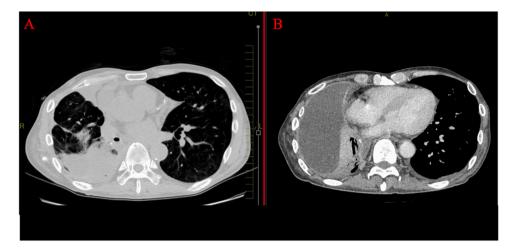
Chest CT. (A) Chest CT performed on admission (lung windowing) shows a slight infiltration shadow and pleural effusion in the lower right lobe. (B) Chest CT performed on day 8 (mediastinal windowing with contrast) shows an encapsulated pleural effusion. Abbreviation: ICU, intensive care unit; CT, computed tomography.
